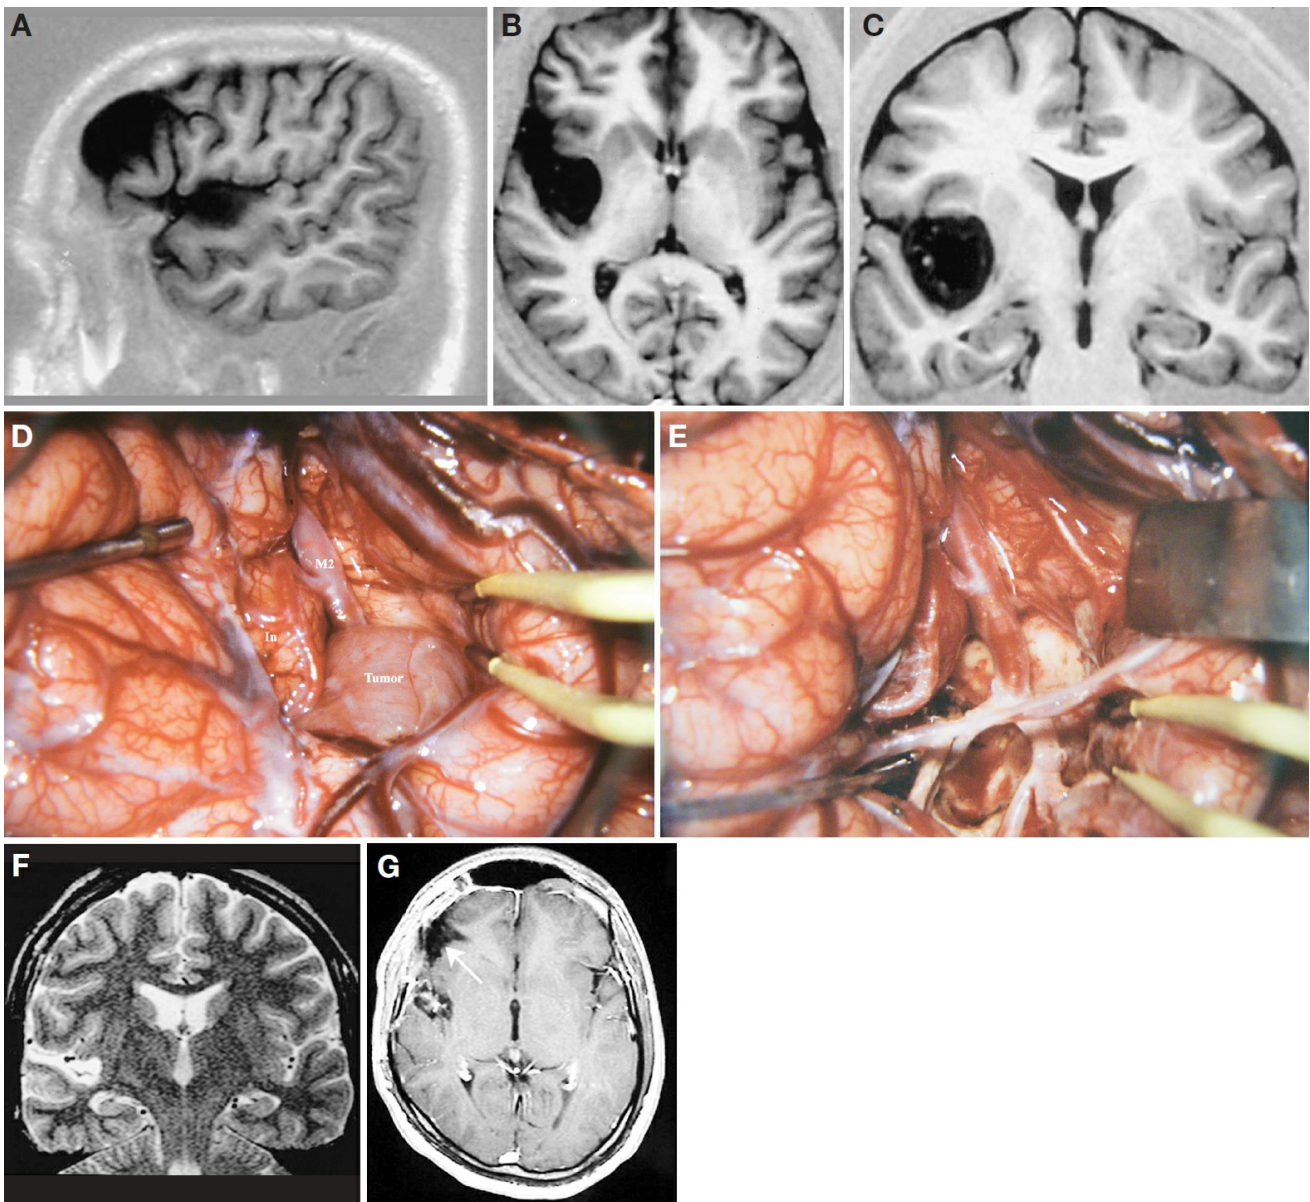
A, sagittal MRI scan of the right hemisphere, depicting an insular tumor and a frontal arachnoidal cyst. B, axial MRI scan. The tumor occupies the posterior two-thirds of the insula, sparing the first 2 short gyri (anterior and middle short gyri) and also sparing the posterior long gyrus. The tumor is limited medially by the lentiform nucleus. C, coronal MRI scan. The superior limit of the tumor is located at the same level of the lateral opercular compartment of the sylvian fissure. D, surgical exposure after an extended right pterional craniotomy, followed by the dural opening and the sylvian fissure splitting. M2, insular segment of the MCA; In, insula. Note that the tumor has encased the MCA. E, final aspect of the brain after tumor removal. The branches of the MCA were preserved. The whitish color of the arteries was owing to frequent application of the papaverine to prevent vasospasm. F, postoperative coronal MRI scan performed 8 months after surgery. G, postoperative
